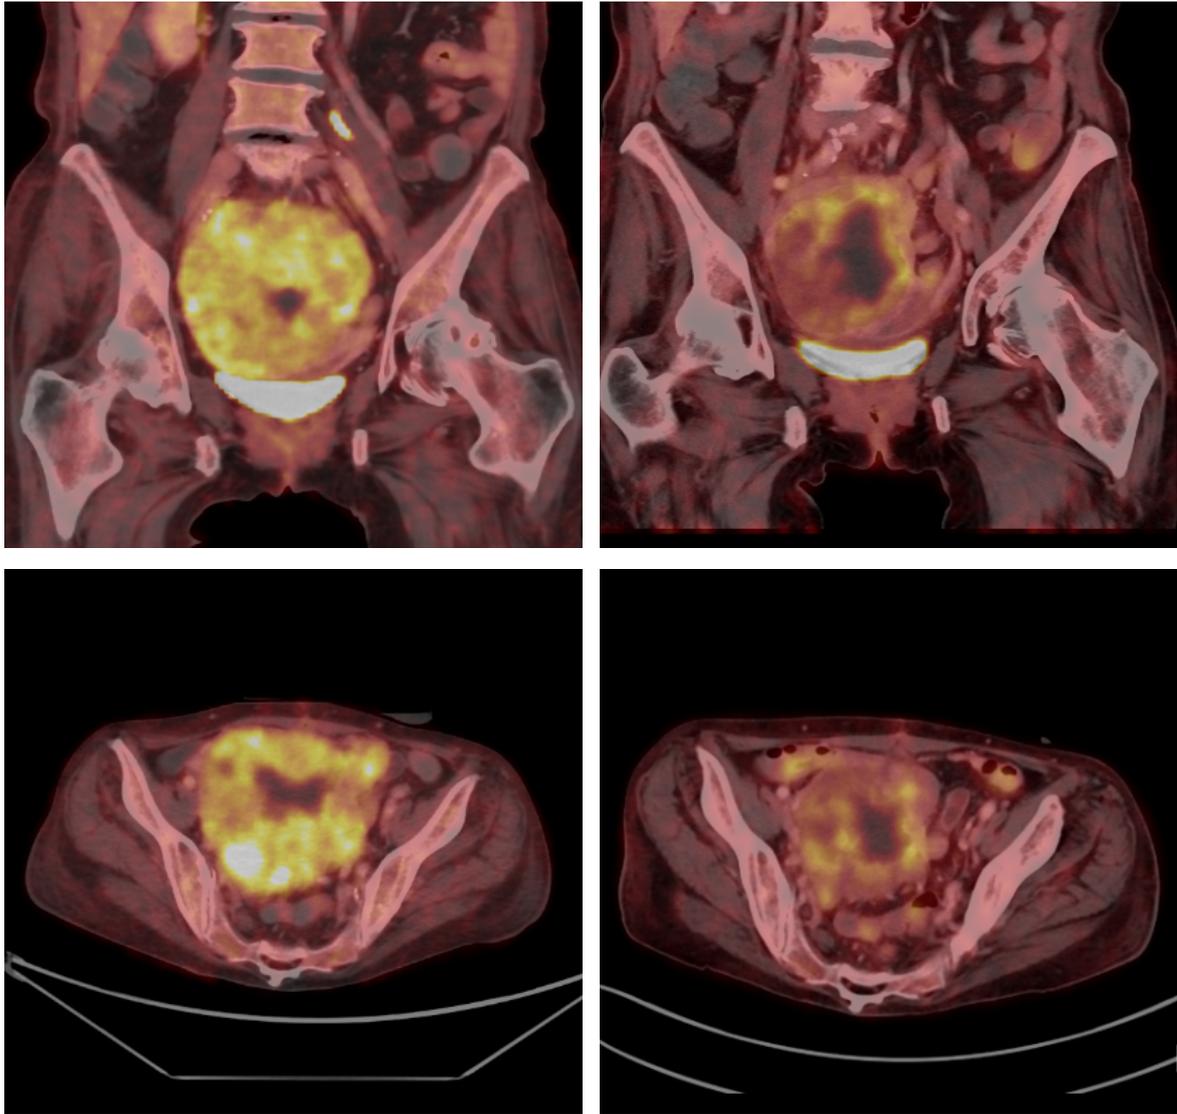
Small-intestinal GIST in the pelvis during neoadjuvant treatment with imatinib, 400 mg daily. Left panel FDG-PET/CT before start of treatment, right panel FDG-PET/CT four weeks after start of treatment, showing decreased metabolic activity and decreased size of the tumor. Mutation analysis showed an insertion in *c-kit* exon 11.
